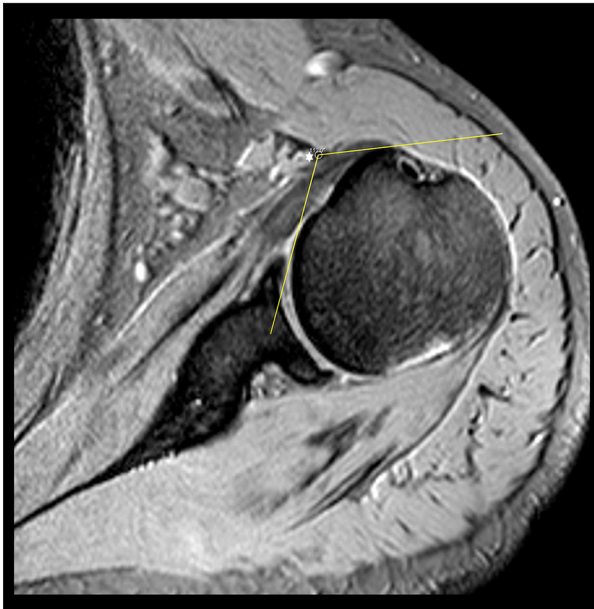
Coracoglenoid angle, in axial T2-weighted FFE images (white\*; coracoid distal tip).
